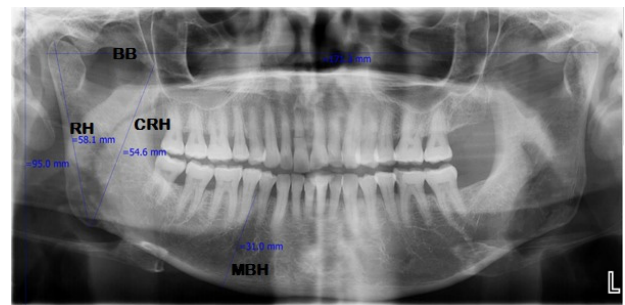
Digital Orthopantomography of Mandibular Variables.
